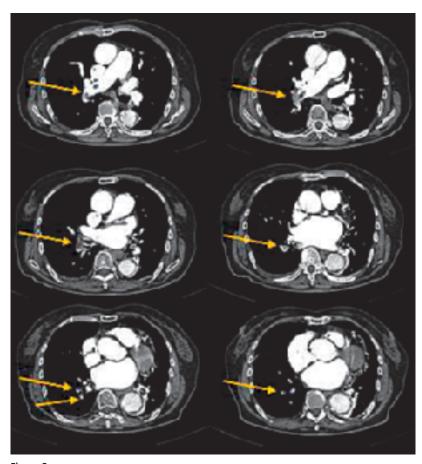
Multi-detector row CT showing a central clot in the right main pulmonary artery extending in the right lower lobar artery and its segmental branches.
